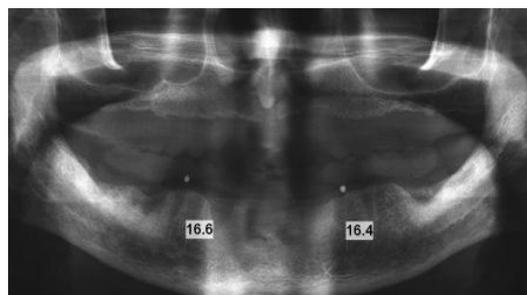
OPG taken with radiographic guide showing the distance from mental foramen
